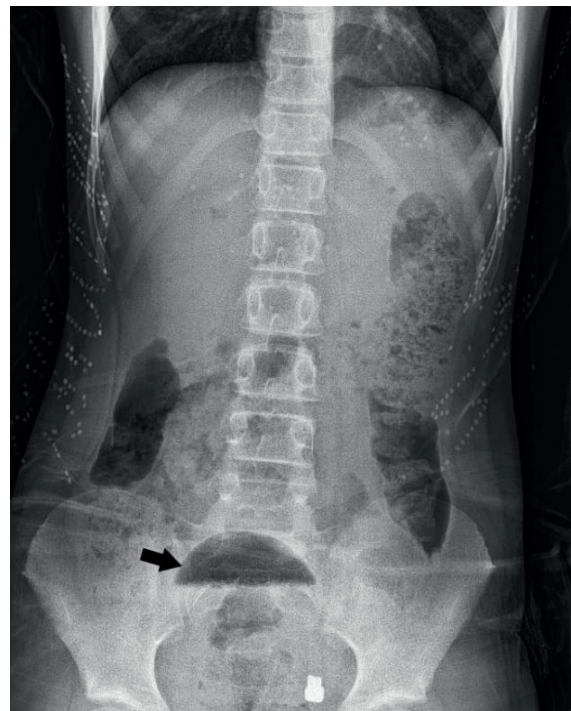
Level of gas formation in the bladder on the standing abdominal X-ray (black arrow).
